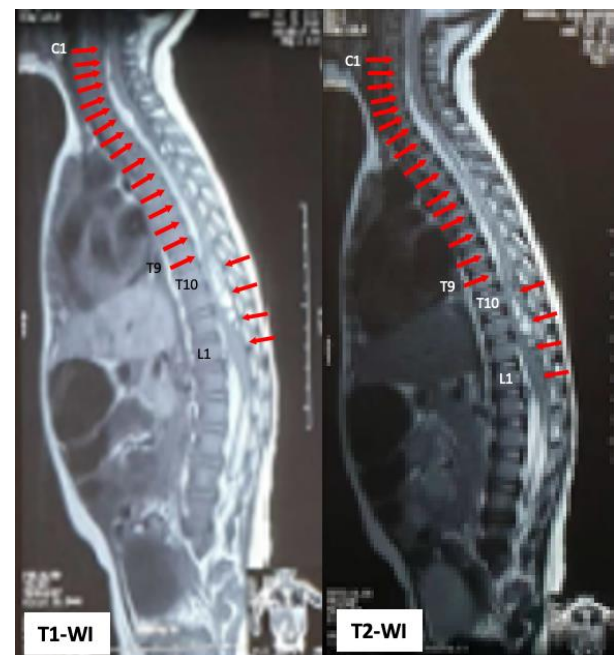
MRI of whole spine sagittal T1-weighted image and T2-weighted image revealed a subacute subdural hematoma extending from C1 to T9 on anterior aspect, then T10 to L1 on posterior aspect.
